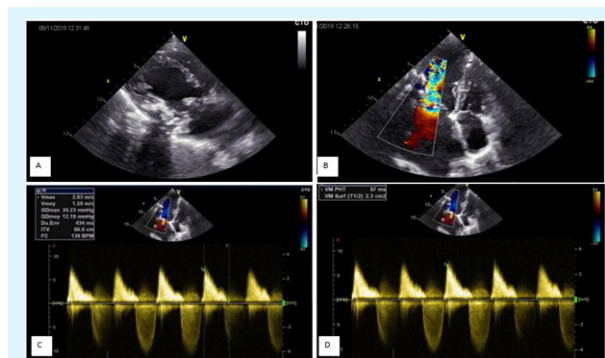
Echocardiographic findings: A: Parasternal long axis view showing severe calcification of the basal inferolateral segment extending to the posterior leaflet of mitral valve with a shadow cone. B: 4 apical chamber view (Left ventricle in the left) showing aliasing flow due to mitral stenosis diastolic gradient. C: Continuous wave doppler applied on the mitral valve inflow showing an elevated gradient: mean gradient = 12 mmHg. D: Continuous wave doppler across the mitral valve inflow, PHT=97 ms.
